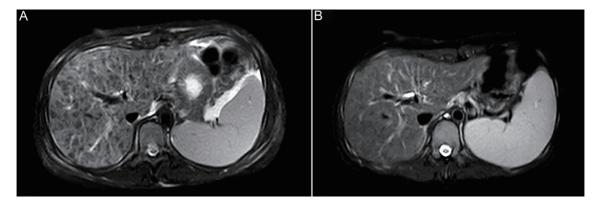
Imaging findings of the patient before and after treatment. Magnetic resonance imaging of the upper abdomen of a 13-year-old girl. (A) T2 low-signal nodules with unclear boundaries, considered cirrhotic nodules; splenomegaly and ascites; (B) After one year of treatment with zinc gluconate (seven tablets/day) combined with penicillamine (four tablets/day), the T2 low-signal nodules were significantly reduced, and no ascites were seen.
